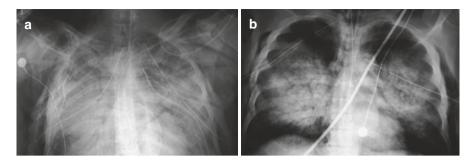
Severe primary blast lung injury. Chest X-rays showing presence of multiple chest tubes inserted to treat severe primary blast lung (a, b)
